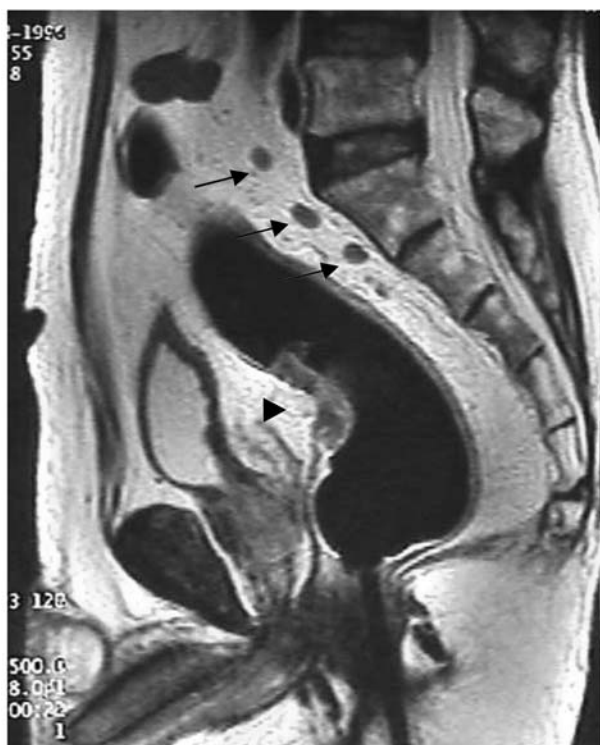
Rectal carcinoma and lymph node metastasis on MRI. (stage T3, N1) (T2-weighted imaging, sagittal section). Arrows indicate metastatic lymph node from 6 to 10 mm in longitudinal diameter with ellipse shape and minor heterogeneous internal structure. An arrowhead indicates the tumor.
